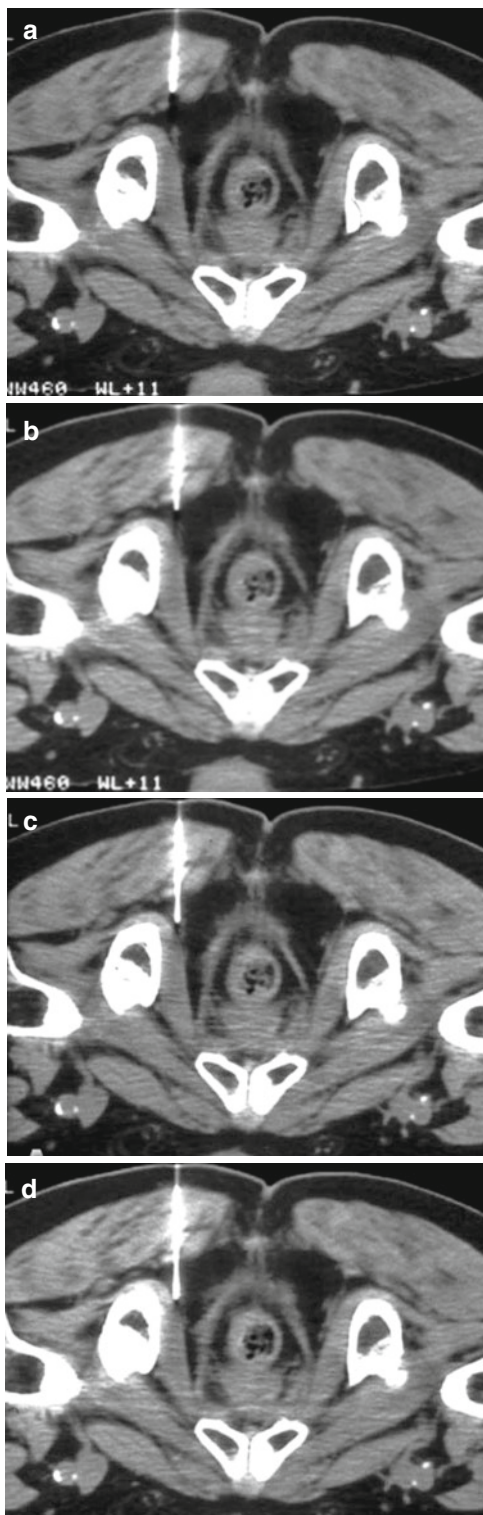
Pudendal nerve infiltration second site: CT shows the progress of the needle tip on the right to Alcock's canal (a-c) abutting the pudendal nerve (d; second site)
